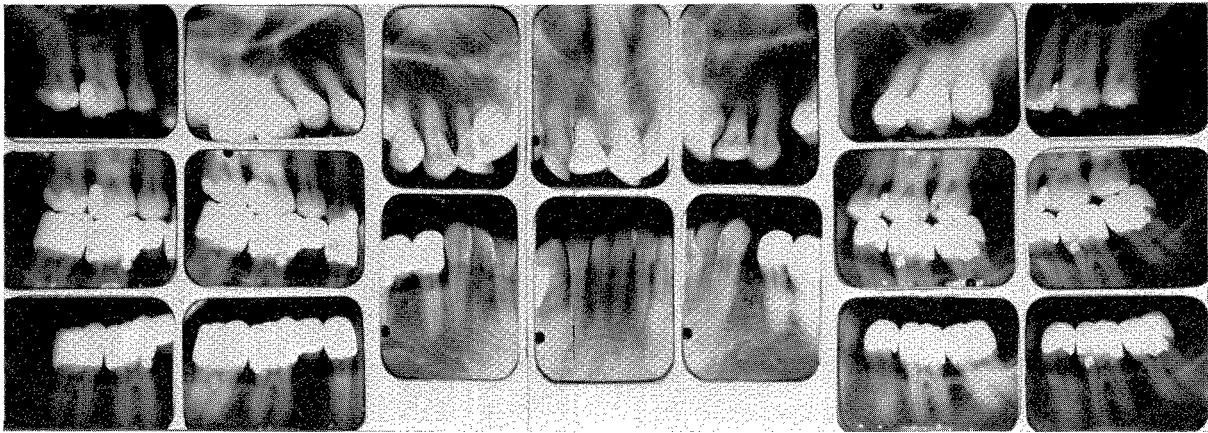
Roentgenograms of the case shown in Fig. 696 showing the teeth and structures one year after the introduction of the lower prosthesis.
